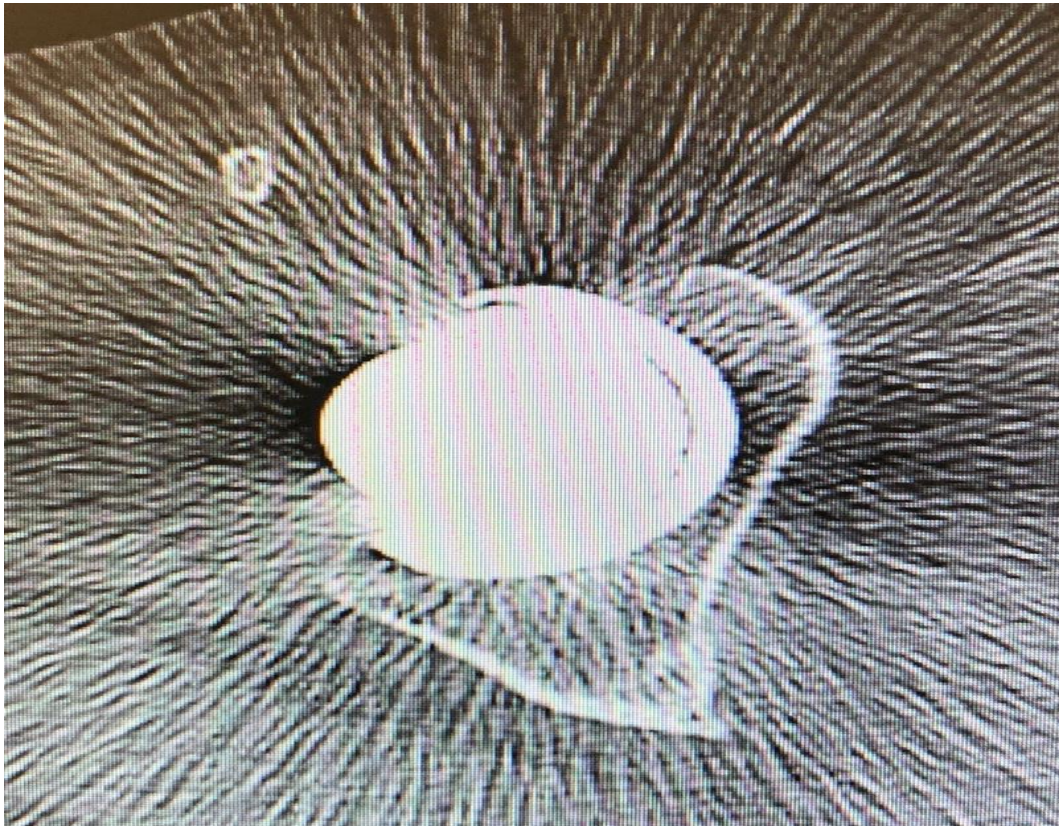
CT scan showing uncovergae of the Acetabular component.
